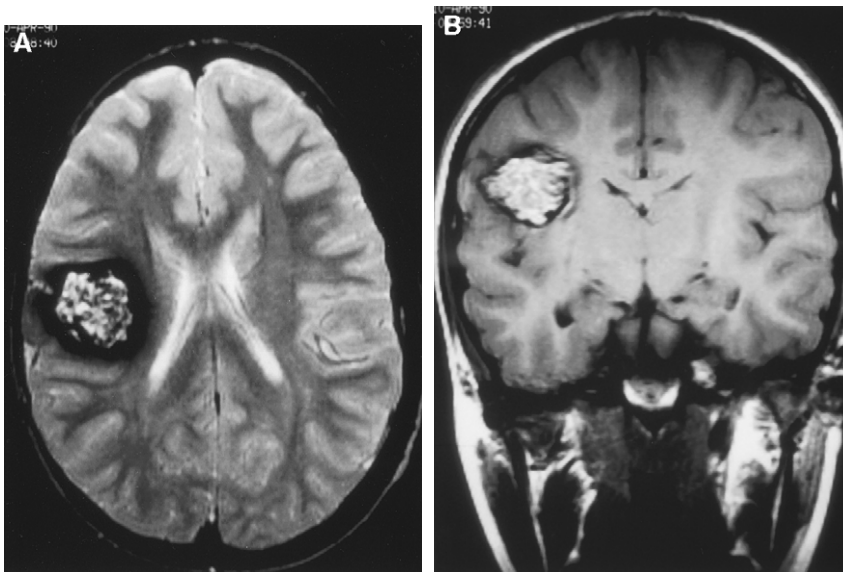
Typical appearance of cavernous malformation on T2-weighted (A) and T1-weighted (B) images.
